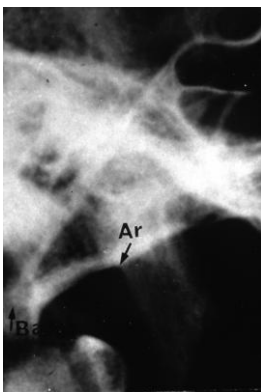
Landmark Articulare (Ar): On the skull (top) the reference point does not exist; it becomes apparent only in the superimposition of the structures on the cephalometric X-ray. At the bottom right the common double contours can be seen.
